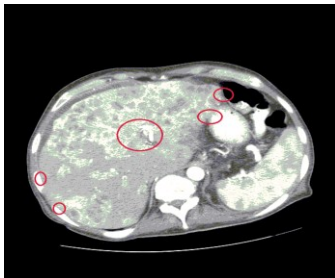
CT of Abdomen, Liver with different pattern structures (Courtesy, MD Anderson Cancer Center).
